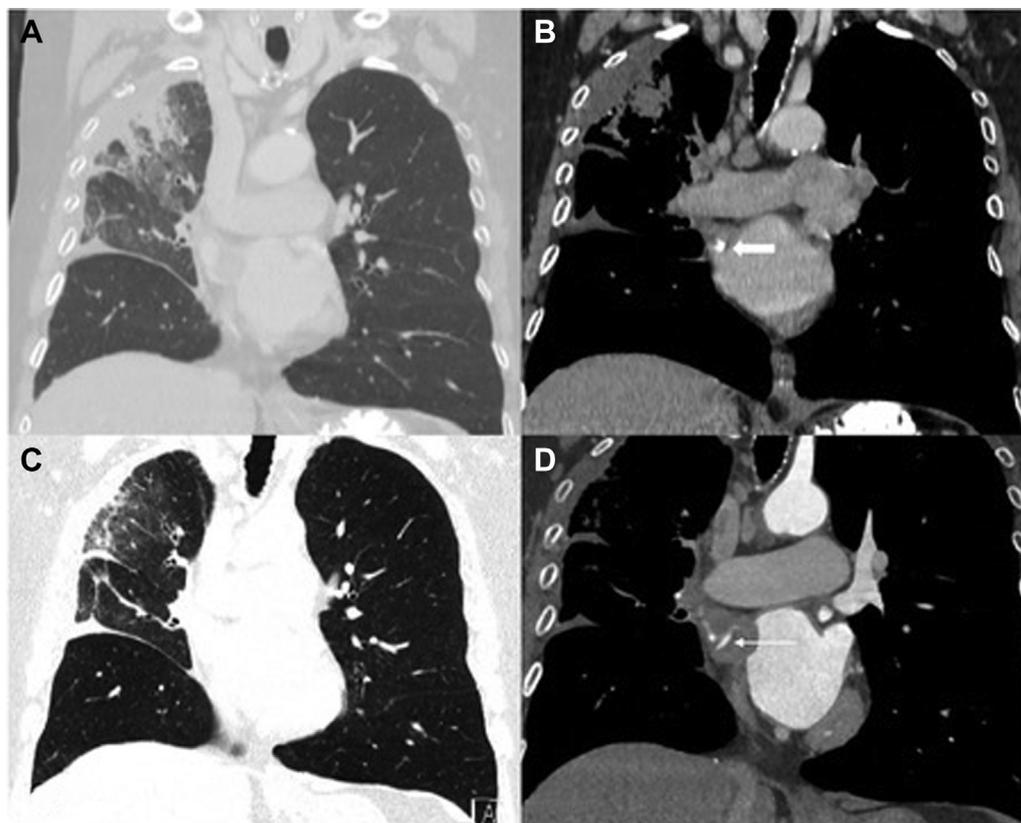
Coronal enhanced chest CT with images A and B performed 6 weeks prior to C and D. A and B demonstrate pulmonary venous infarct in the right upper lobe related to a right superior pulmonary vein thrombus with a peripheral calcification (thick arrow). Six weeks later, the pulmonary infarct has improved (C) with enhancing serpiginous structure within the thrombus (D), likely a recanalized thrombus (thin arrow).
